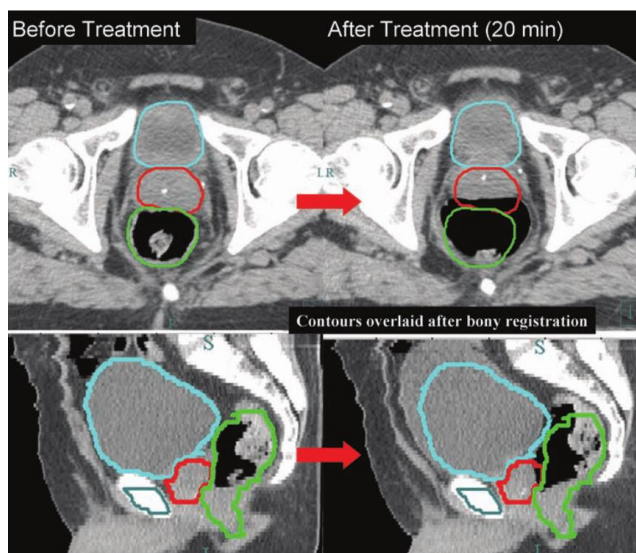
Intra-fractional shifts of prostate after treatment. CT images were obtained before and after the IMRT treatment. Prostate (red contour) was shifted anteriorly for >5 mm. The other structures showed in a figure are: rectum (green contour) and bladder (blue contour) [49]
